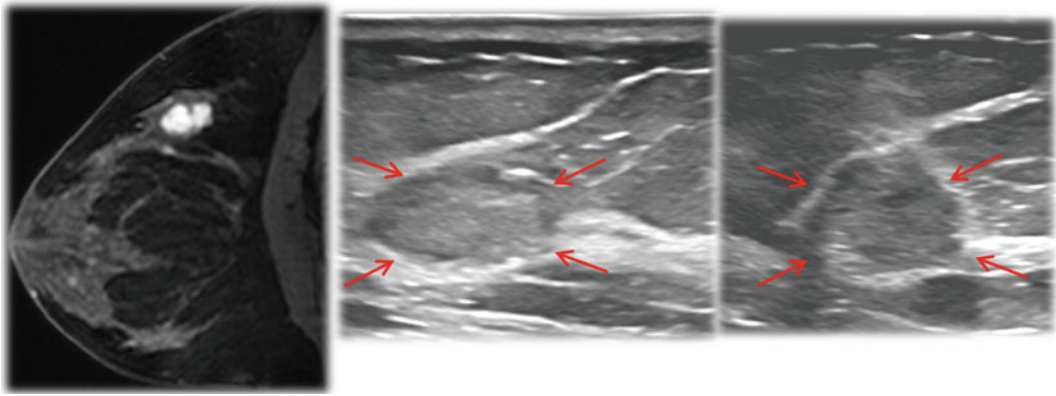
Mixed mucinous carcinoma: MRI shows an enhancing lesion. Targeted ultrasound revealed an isoechoic (easily overlooked) lesion
